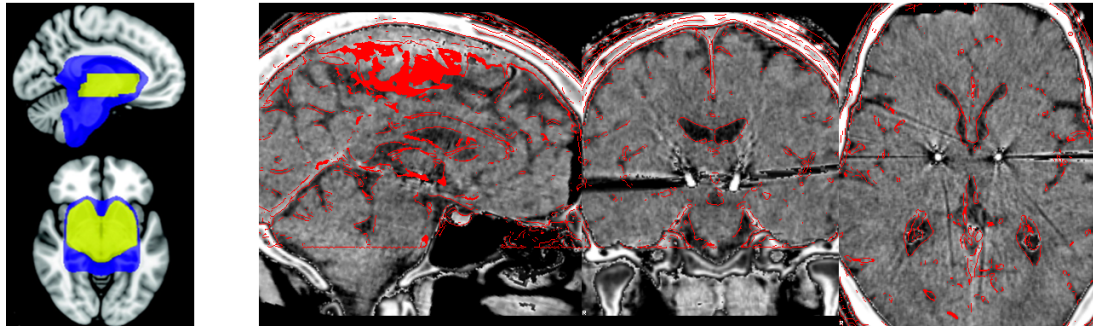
Normalization of post-operative CT to the MNI2009b space, previously registered to preoperative MRIs.
